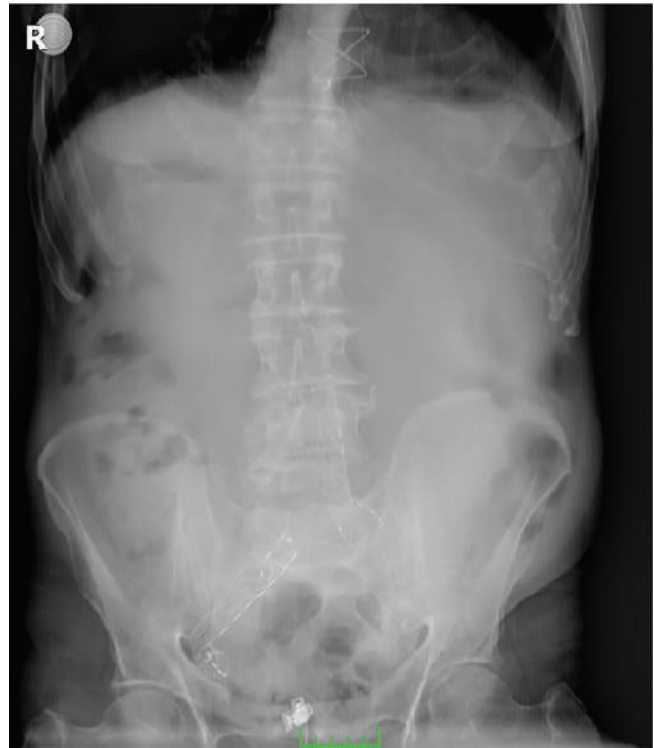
X-ray. Preoperative upright abdominal radiograph.
